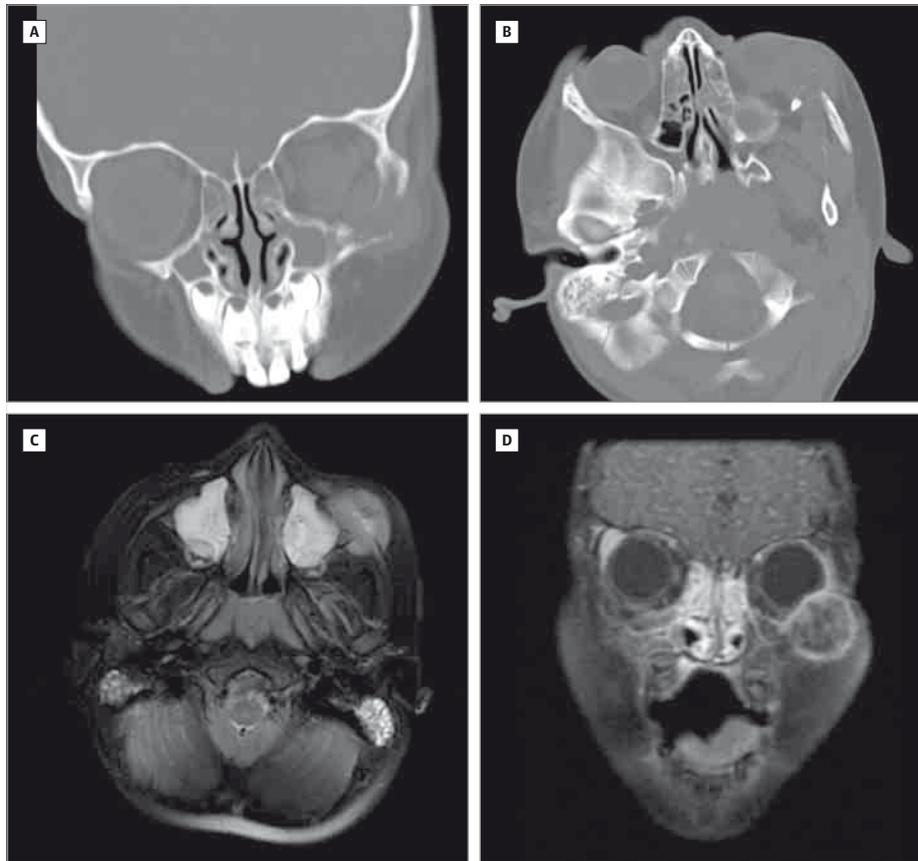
A and B, Computed tomographic images of the maxillofacial region showing a round, soft-tissue mass. A, Coronal view. B, Axial view. C and D, Magnetic resonance imaging (MRI) scans of the maxillofacial region; C, T2-weighted MRI scan, axial view. D, Postcontrast T1-weighted MRI scan, coronal view.
